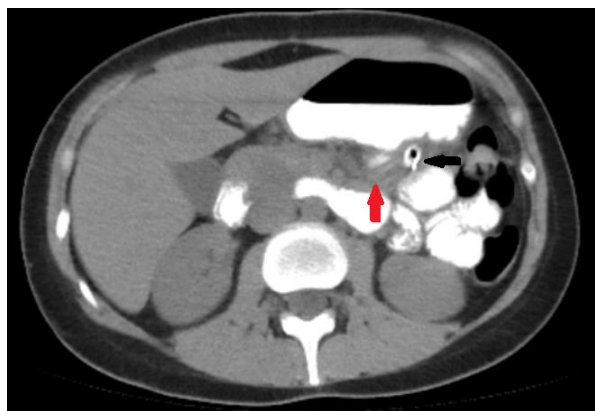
Oral and intravenous contrast abdominal CT highlights extravasation of the contrast substance through a 3 mm diameter orifice at duodenum IV level evidenced laparoscopically
